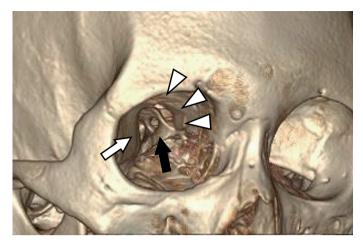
Three-dimensional computed tomography showing an orbital roof fracture. The intracranial entrance created by the fracture (arrowheads) is observed on the medial side of the superior orbital fissure (white arrow) and optic canal (black arrow).
